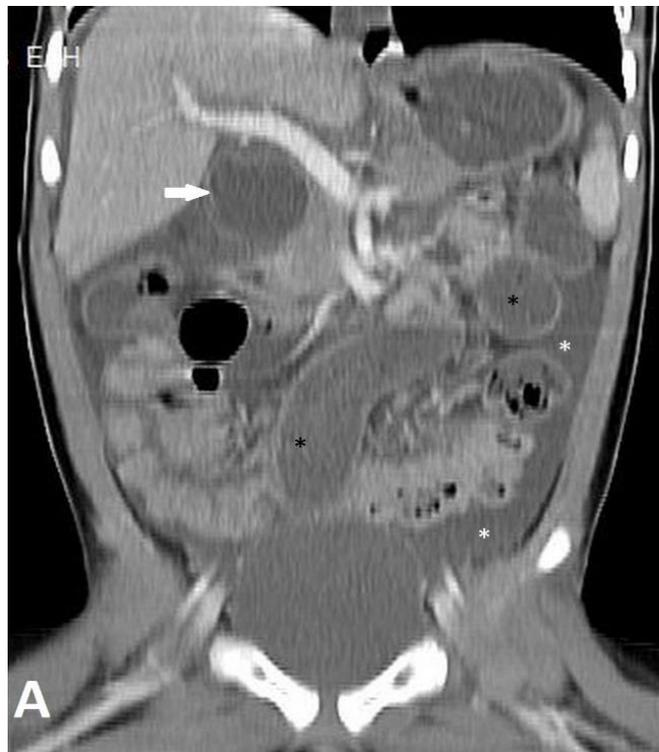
(A,B) : Coronal CT (A),sagittal CT (B) images,shows a cystic structure measuring 3 cm in diameter beside the pancreatic head (white arrow) , the free fluid is seen at paracolic areas (white asterisks), and dilated bowel loops (black asterisks).
